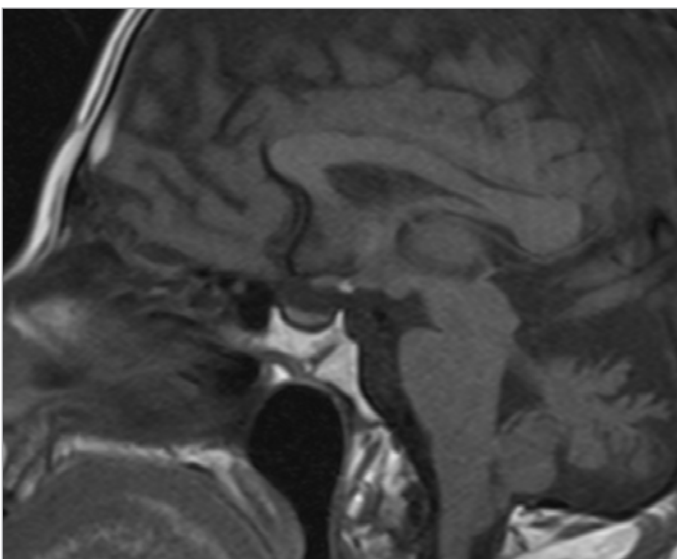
Hypophysis MRI t1 sagittal. Loss of pituitary stalk shown.
